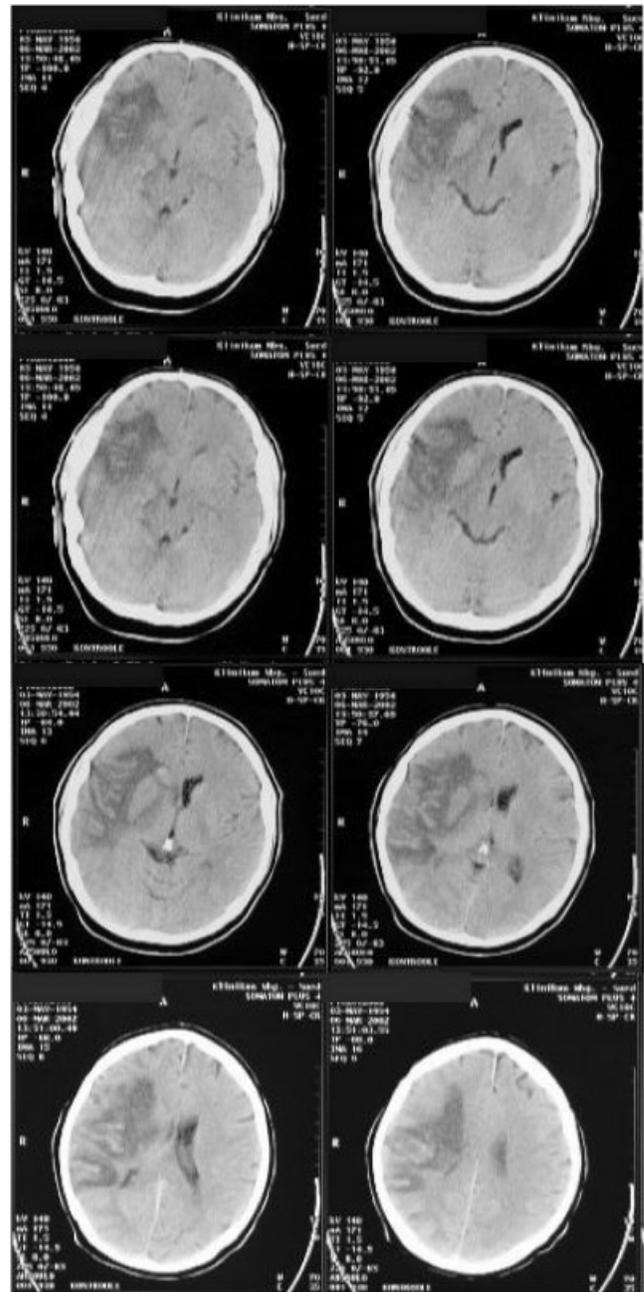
CT-scan (horizontal slices) of patient EG.
